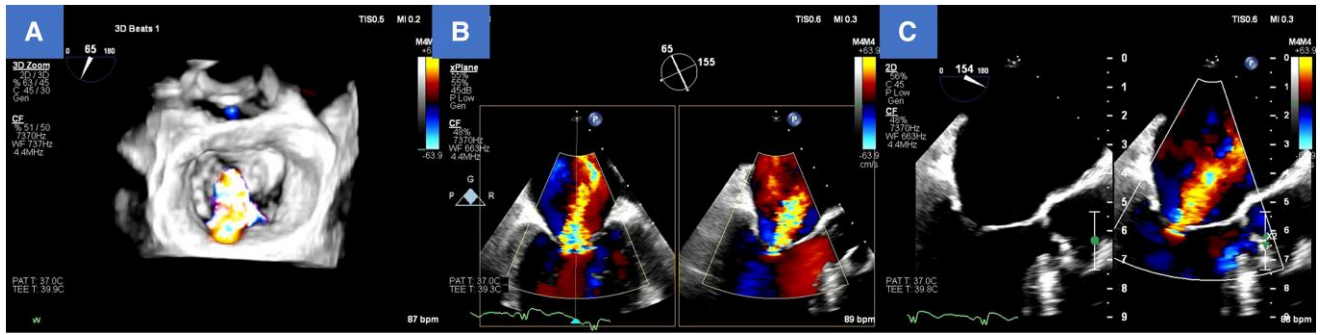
Pre-operative transoesophageal echocardiography. (A) Three-dimensional image of the mitral valve showing a central jet from A2–P2. (B) Wide regurgitation jet slightly lateral to A2–P2. (C) Posterior mitral leaflet was tethering, PML length around 8 mm.
